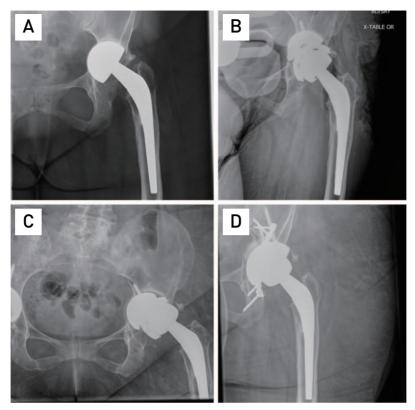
(A) Preoperative anteroposterior (AP) pelvis X-ray of example case 3 demonstrating massive anterosuperior medial bone loss in a case of failed bipolar hemiarthroplasty. (B) Postoperative AP pelvis X-ray of example case 3 demonstrating management using the dome technique. (C) AP pelvis X-ray taken after a fall demonstrating a transverse acetabulum fracture through the dome technique construct. (D) AP pelvis X-ray taken after re-revision of the hip arthroplasty. An open-reduction internal fixation of the acetabulum was performed with placement of a porous metal acetabulum shell and a bipolar femoral head.
